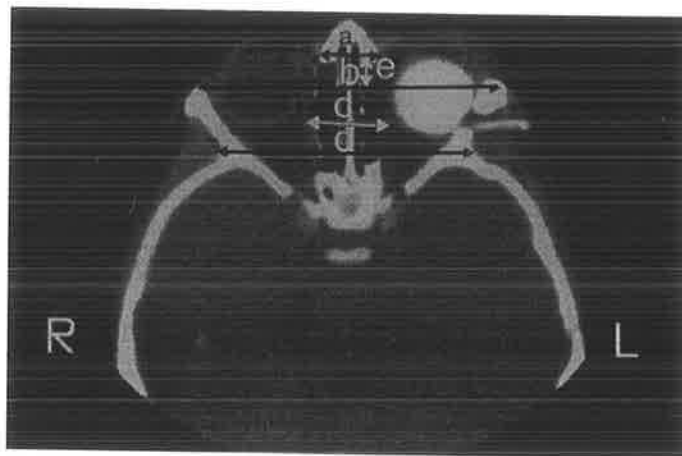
CT measurements in the orbital region. (after Waitzman et al.⁹). The parameters measured are demonstrated on axial CT scans from our series. A partially inflated expander can be seen in the left orbit with the injection port tubing emerging through a hole in the lateral orbital wall into the temporal fossa.
